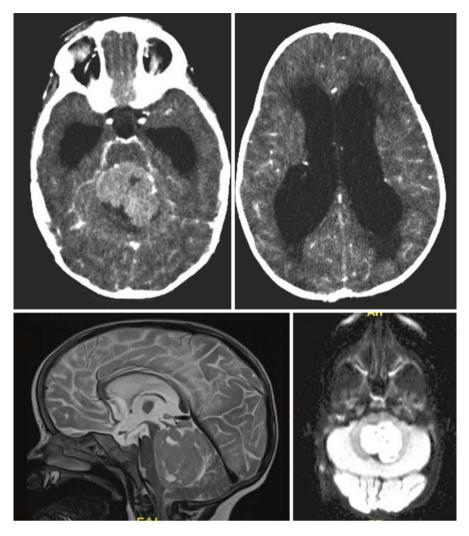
Medulloblastoma: CT scan of a 14-month-old boy presenting in a deteriorated condition secondary to hydrocephalus secondary to a posterior fossa tumor. The child was shunted. Sagittal T2 and axial diffusion MRI showing a fourth ventricle medulloblastoma. The tumor was resected
